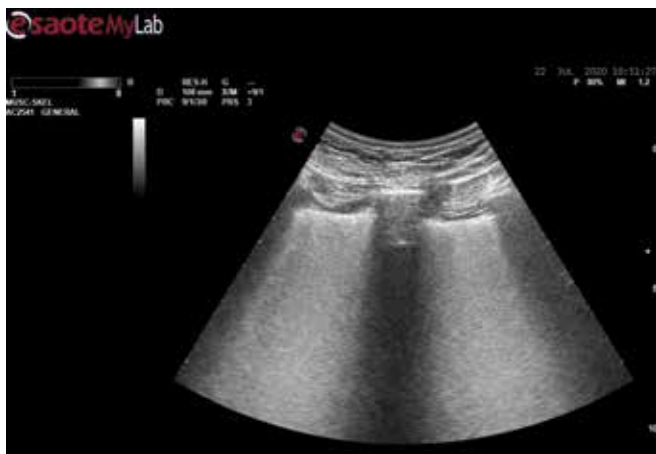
Lung ultrasound shows confluent B-lines
